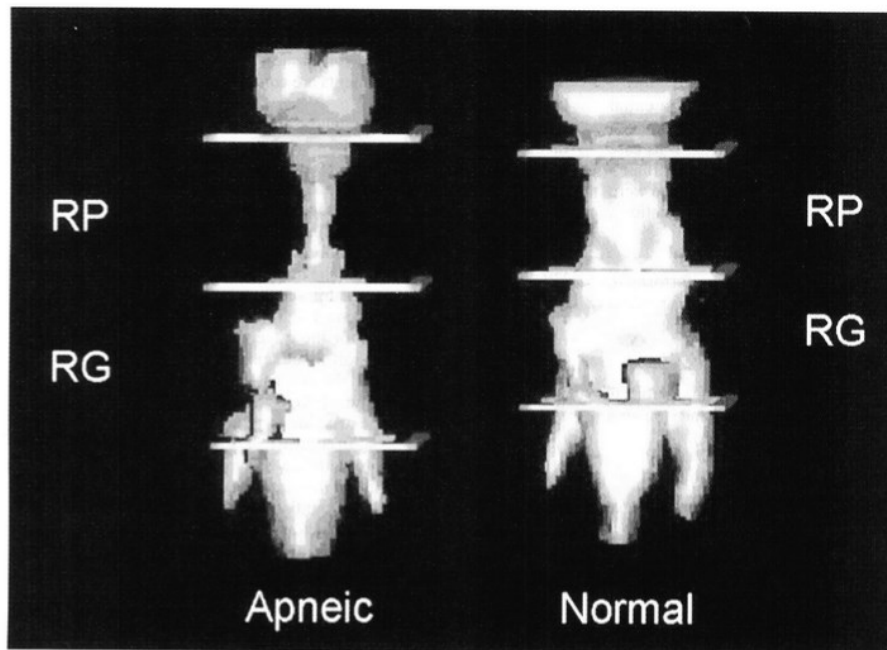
Airway volume in patient with sleep apnea (left) and normal subject (right). Upper airway volume is small in the retropalatal region and the lateral dimension is significantly reduced in the subject with OSA. Reprinted with permission; Schwab RJ, Pasirstein M, Pierson R, et al. Identification of upper airway anatomic risk factors for obstructive sleep apnea with volumetric magnetic resonance imaging. *Am J Respir Crit Care Med.* 2003;168(5):522-530
